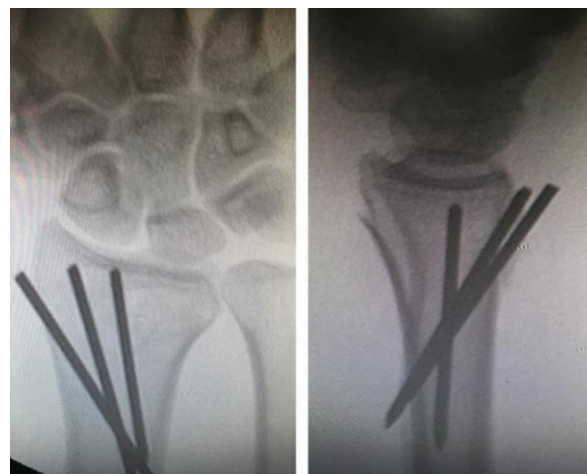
Postop X-ray Ap & Lateral View
